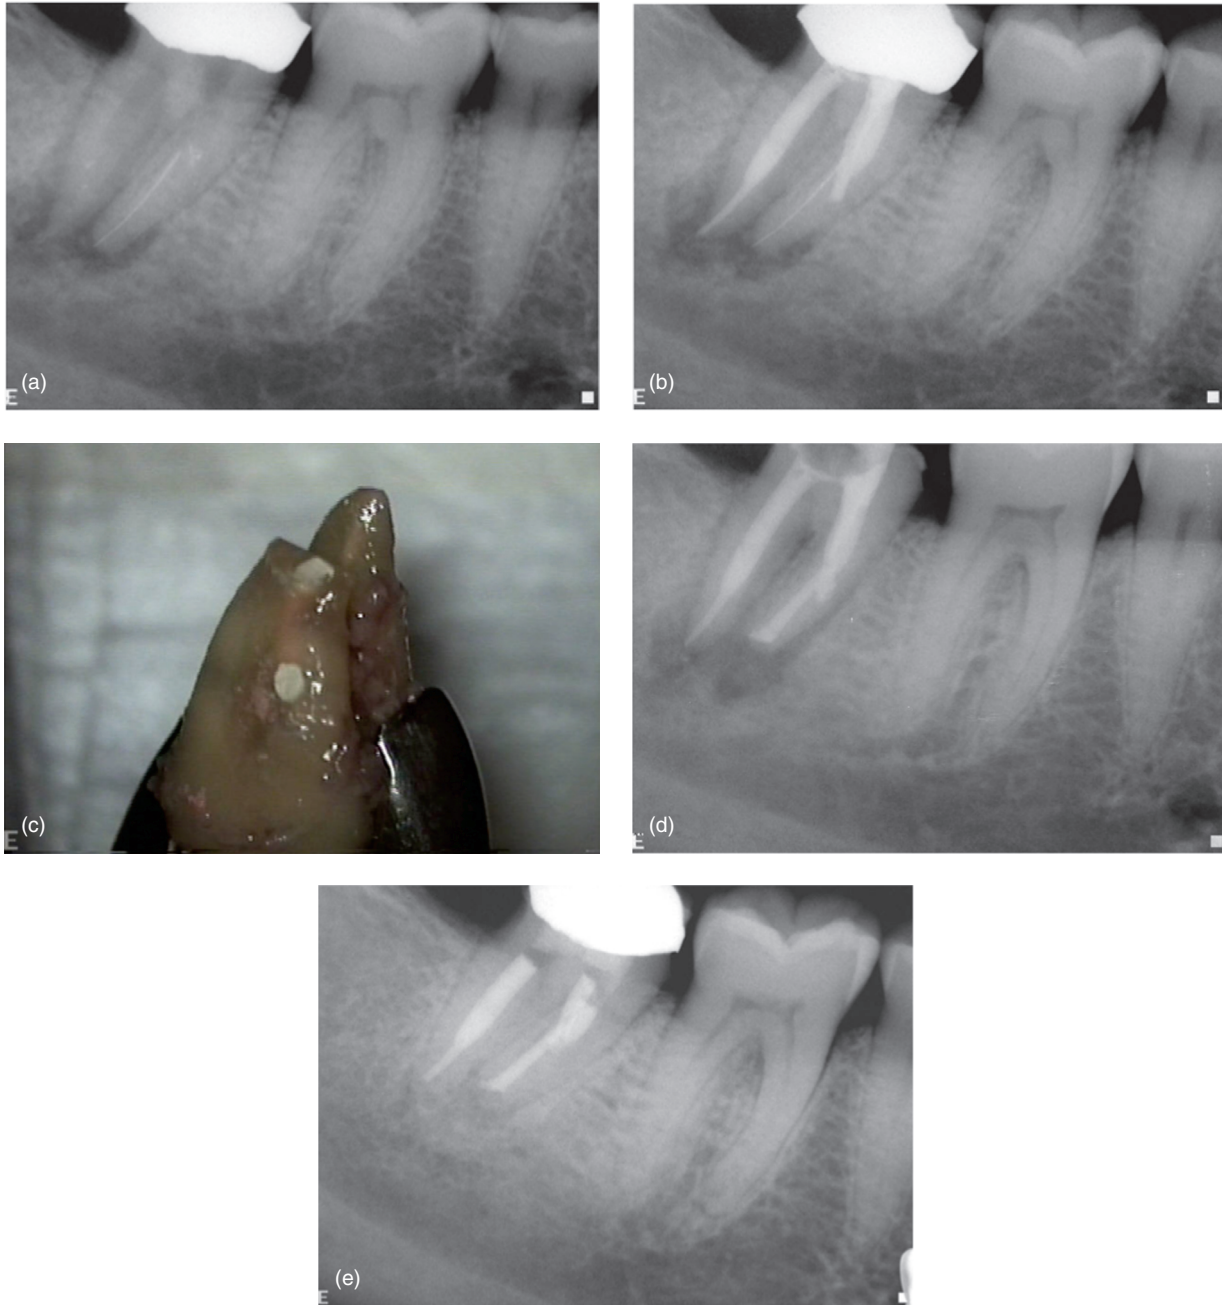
Mandibular right second molar with separated instrument and perforation in the mesial root, referred to endodontist. (a) Preoperative radiograph. (b) Postoperative conservative treatment. (c) Mesial root extraorally with apex and perforation site sealed with SuperEBA cement. (d) Postop radiograph. Note that after removal of the separated file extraorally, there was a large portion of the mesial canals unfilled, so they were retroinstrumented with NiTi rotary files and retrofilled with warm gutta percha, followed by immediate root end resection and preparation of root end as well as perforation with high speed 330 bur. They were then repaired with SuperEBA cement. (e) Four year follow-up showing complete healing and a new crown. (Courtesy of Dr Steve Leveson.)
